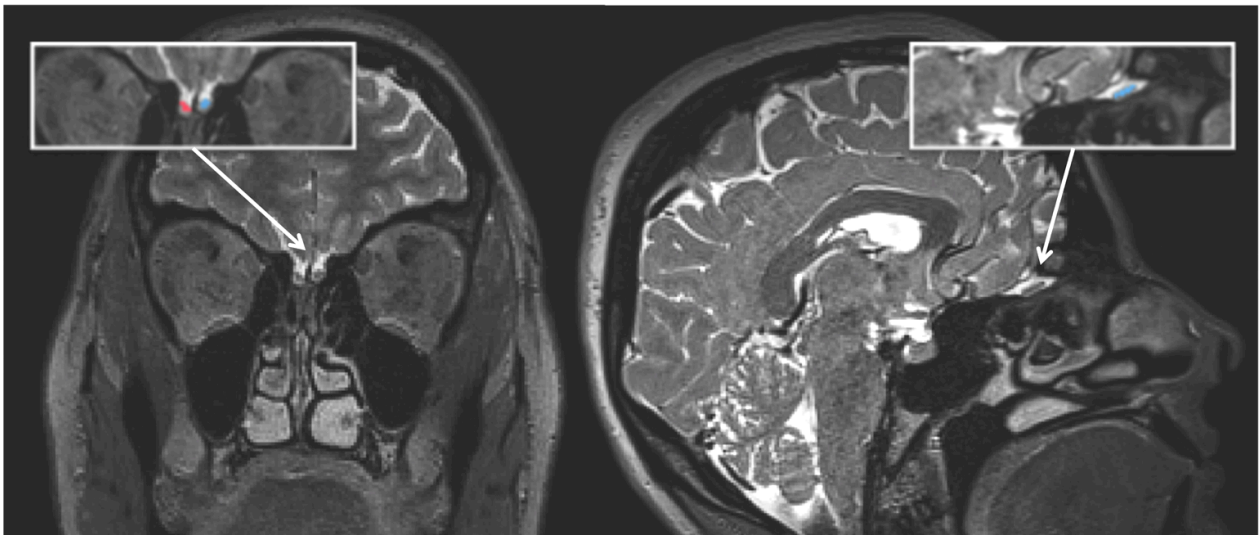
Coronal and sagittal depictions of the annotated olfactory bulb volumes (OBVs) on T2-weighted images
